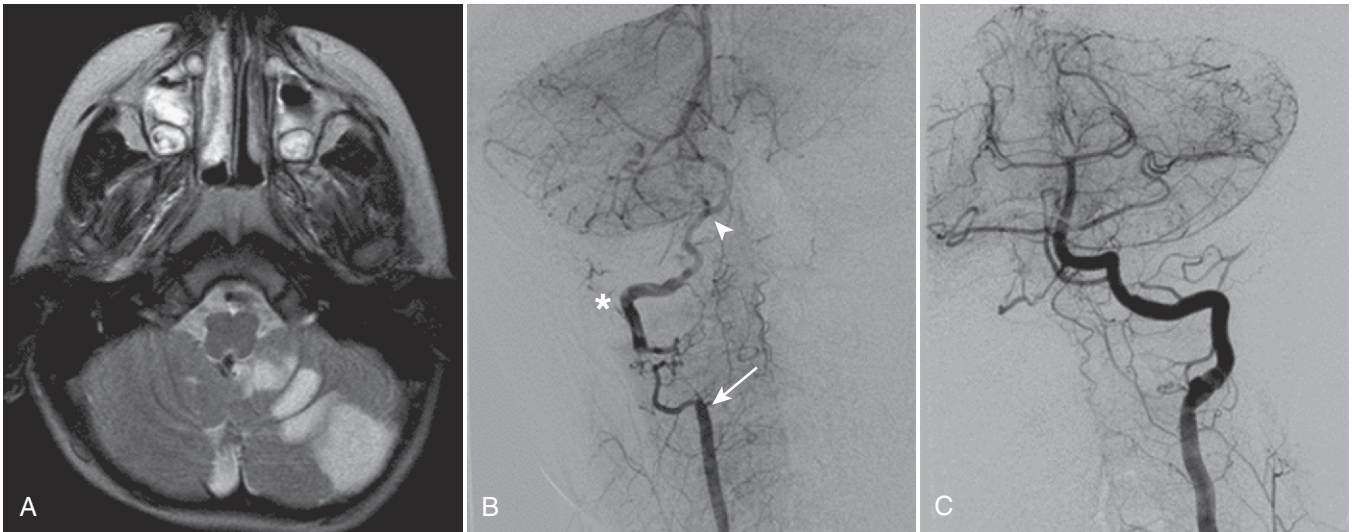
Sudden onset of headache, ataxia, and complaint of dizziness developed in a healthy 3-year-old boy after a fall from a slow-moving vehicle. One week later MRI showed cerebellar stroke (A). Angiogram shows right cervical vertebral artery occlusion (B, arrow) with distal reconstitution (*) from collaterals, reocclusion at junction with basilar artery (arrowhead). Compare to normal left vertebral artery (C).
